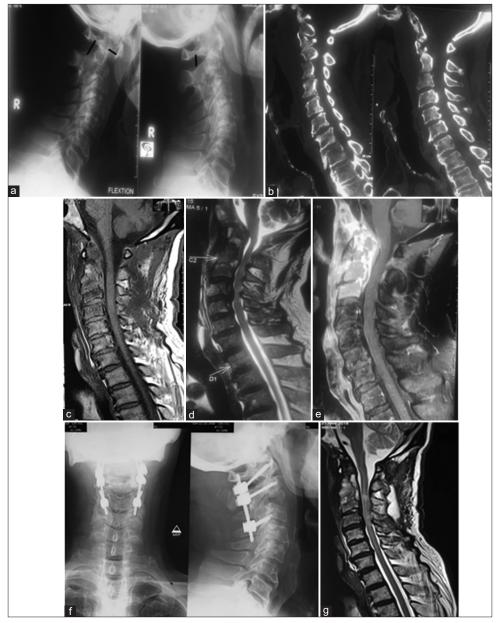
X-ray cervical spine dynamic view showing C1/2 instability, (b) Computed tomography (CT) cervical spine in sagittal view, showing partial erosion of C1 lateral mass and C2 body, (c, d, e) Magnetic resonance imaging (MRI) of the cervical spine, contrast enhancing extradural mass at C1-3 levels causing obliteration of the anterior CSF column and prevertebral collection of abscesses. (f) Postoperative X-ray of the cervical spine at 1 month, showing spinal fixation between C1 lateral mass, C2 pedicle, and C3 lateral mass with screws and rods, (g) MRI of the cervical spine at 6-month complete resolution of abscess and significant decompression of cord.
